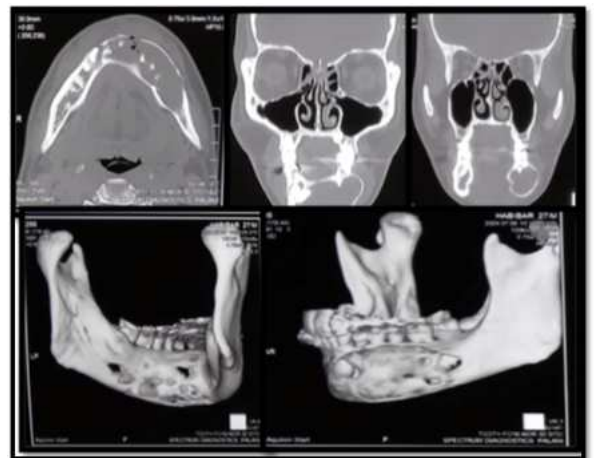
Pre operative Computed Tomography revealing expansile osteolytic lesion involving the mandibular region.
